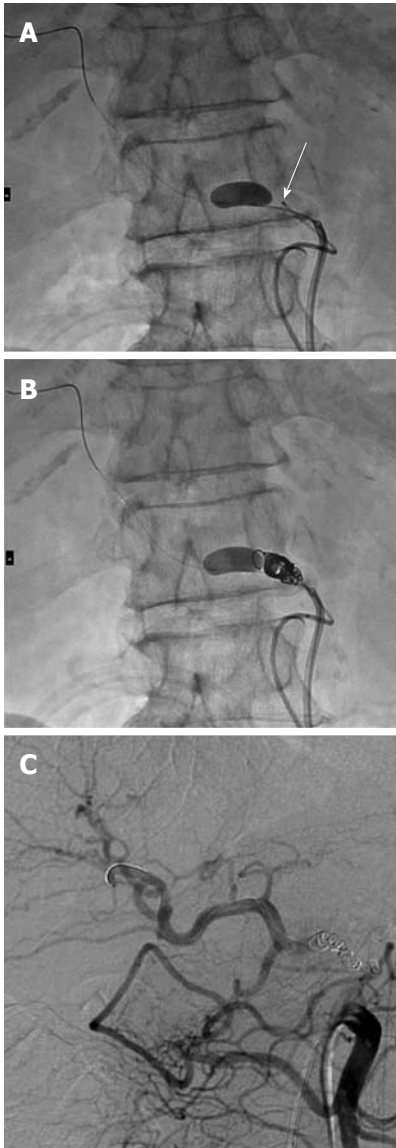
Microcoil embolization under distal balloon inflation. A: Radiograph during catheterization shows microcatheter (arrow) insertion to the common hepatic artery (CHA) via the celiac artery under distal microballoon inflation in the CHA; B: Radiograph during microcoil embolization shows a tight widthwise frame; C: Superior mesenteric arteriography after microcoil embolization shows blood flow from the superior mesenteric artery to the proper hepatic artery via the pancreaticoduodenal arcades.
